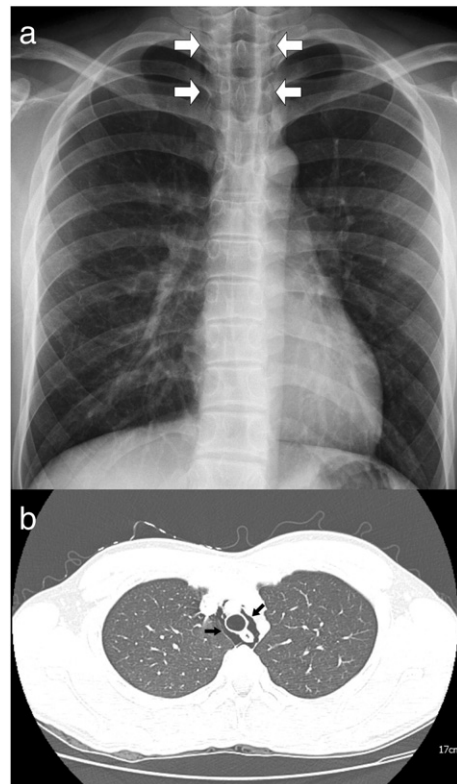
(a) Chest radiograph shows air column around the trachea in the mediastinum (arrows). (b) Computed tomography indicates the presence of interstitial air surrounding the structures within the mediastinal pleura (arrows).
